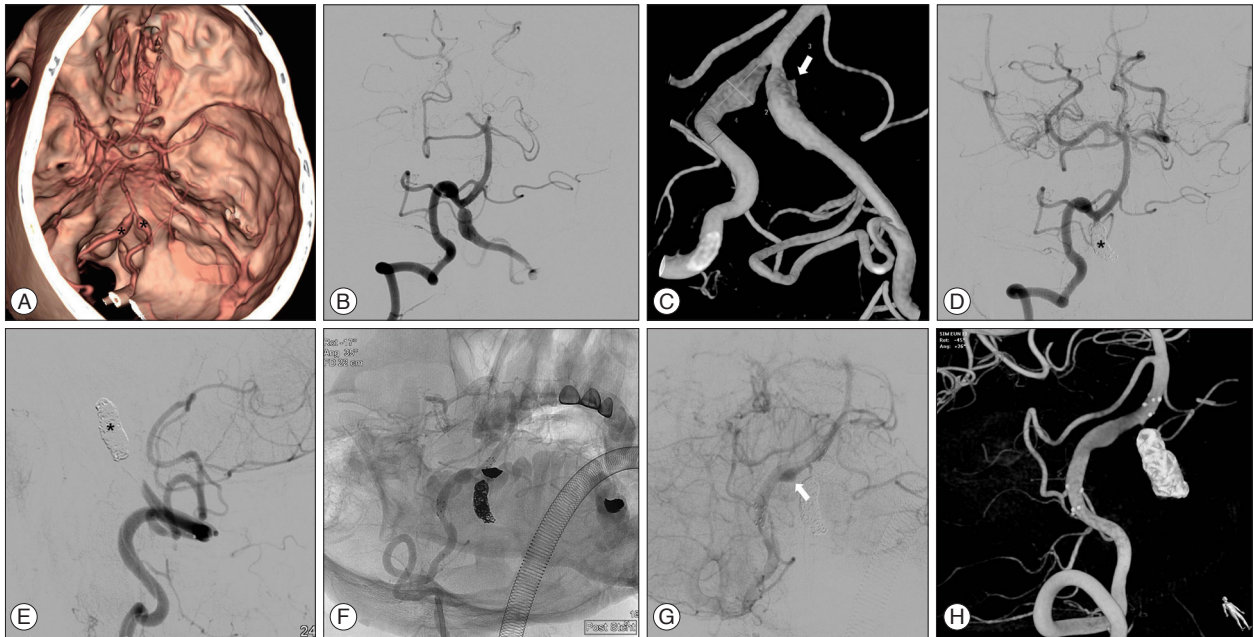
Radiologic findings of endovascular treatment of bilateral vertebral artery dissecting aneurysms (VADAn). A : Three-dimensional brain computed tomography angiography demonstrates bilateral VADAn (asterisks). B : The vertebral angiogram (VAG) shows the dissecting aneurysms in the intracranial portion of the bilateral VAs. C : The three-dimensional rotational angiogram demonstrates that the left VADAn has a bleb-like lesion, which is considered to be the source of the SAH (arrow). D and E : A left VAG obtained immediately after the endovascular trapping using detachable coils (asterisk) shows the complete obliteration of the ruptured VADAn distal to the PICA. F : The right VAG after the staged intervention shows 2 overlapping stents in the dissected vessel. G : After deploying 2 overlapping stents, the definite stagnation of contrast inside the aneurysm is achieved (arrow). H : The three-dimensional rotational angiogram of the right VA demonstrates remodeling of the left VADAn by 2 overlapping stents.
